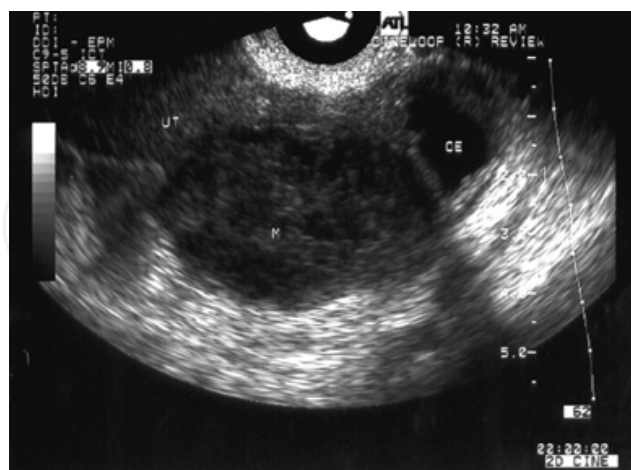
Ultrasound of tubal pregnancy with hematosalpinx (Elito, Camano, 2010a).
